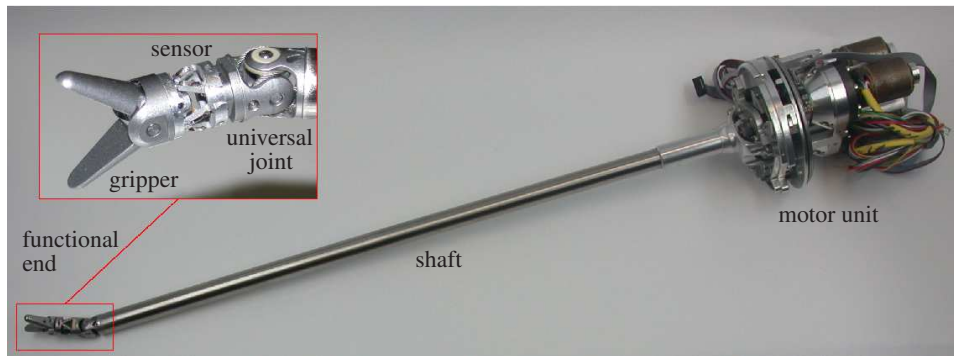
Previous version of the DLR MIRS instrument. The gripper branches are developed in a basic form. In the instrument presented in this thesis the end-effector (gripper) is replaced by the ultrasound transducer, cf. Fig. 1.4 (photos: DLR).
